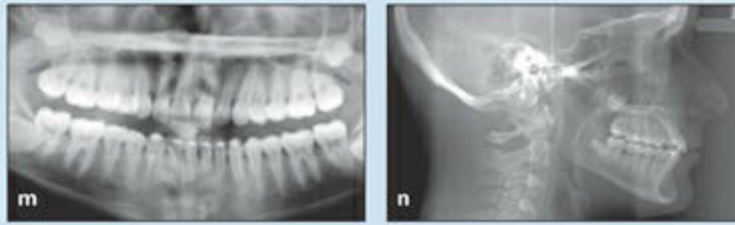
(cont) (m) Posttreatment panoramic radiograph. (n) Posttreatment lateral cephalometric radiograph.
